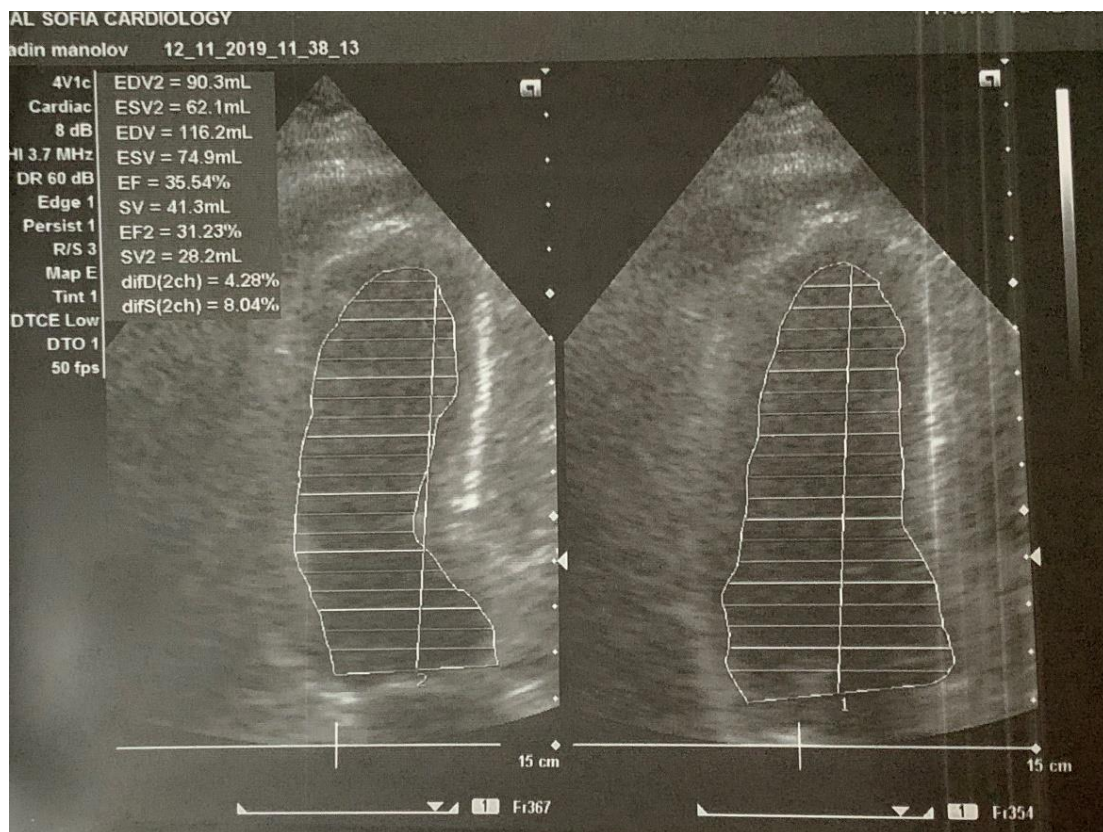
Transthoracic echocardiography.
